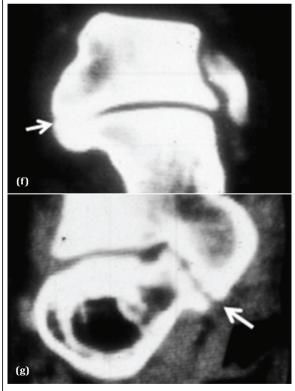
f) CT-complete osseous bridge, g) CT-Fibrous connection.
